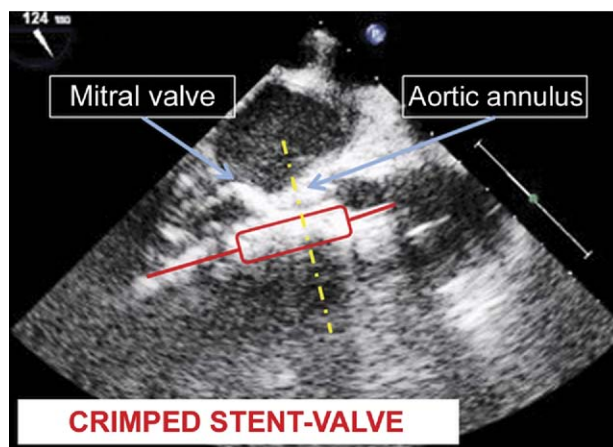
Transesophageal echocardiogram allows for the positioning of the crimped valve across the native aortic annulus. (Key: landmarks are the hinge point of the aortic leaflets, the calcifications, the anterior mitral valve leaflet, and the Valsalva sinuses).
